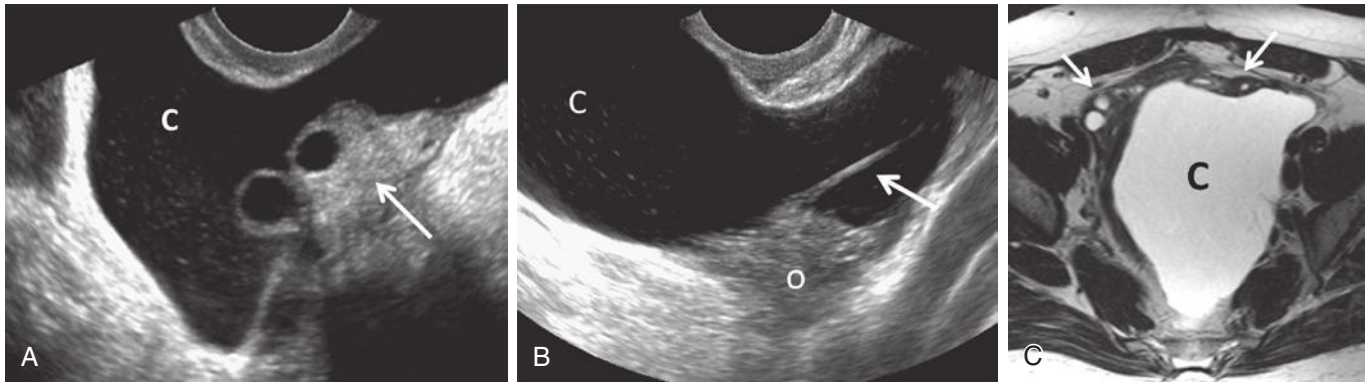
Peritoneal inclusion cyst. A, Normal ovary (*arrow*) identified at the margin of the cyst (*c*), which contains a small amount of echogenic debris. B, A fibrous band (*arrow*) extends from the ovary (*o*). The irregular shape of the cyst (*c*) conforms to adjacent pelvic structures. C, T2-weighted axial magnetic resonance image demonstrates both ovaries (*arrows*) along the anterior wall of the cyst (*c*).
